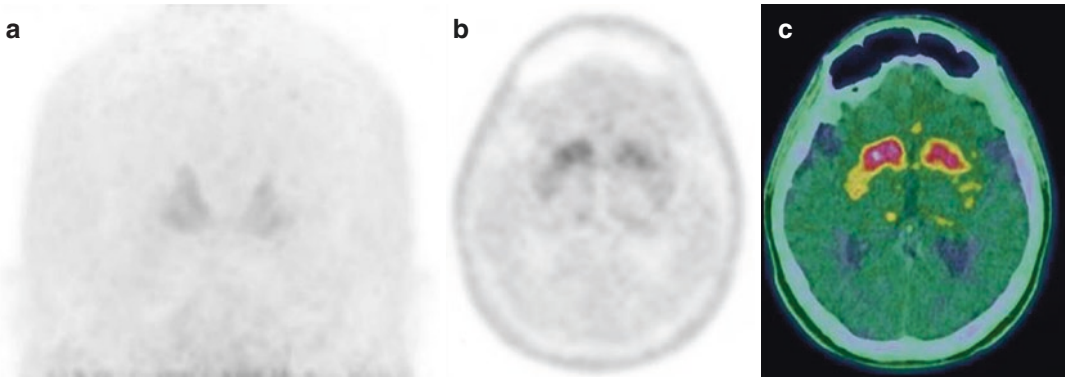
In a patient with Parkinson's disease and predominant right side tremor, PET maximum intensity projection of the brain (a), axial PET (b), and PET/CT (c)
